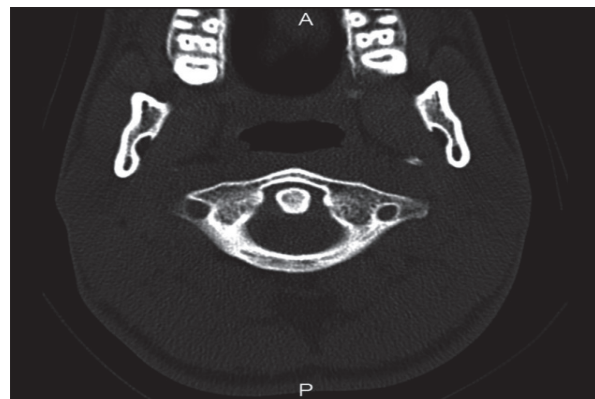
CT Scan of Cervical Spine Revealing Normal C1–C2 Articulation, No Instability and No Evidence of Subluxation
